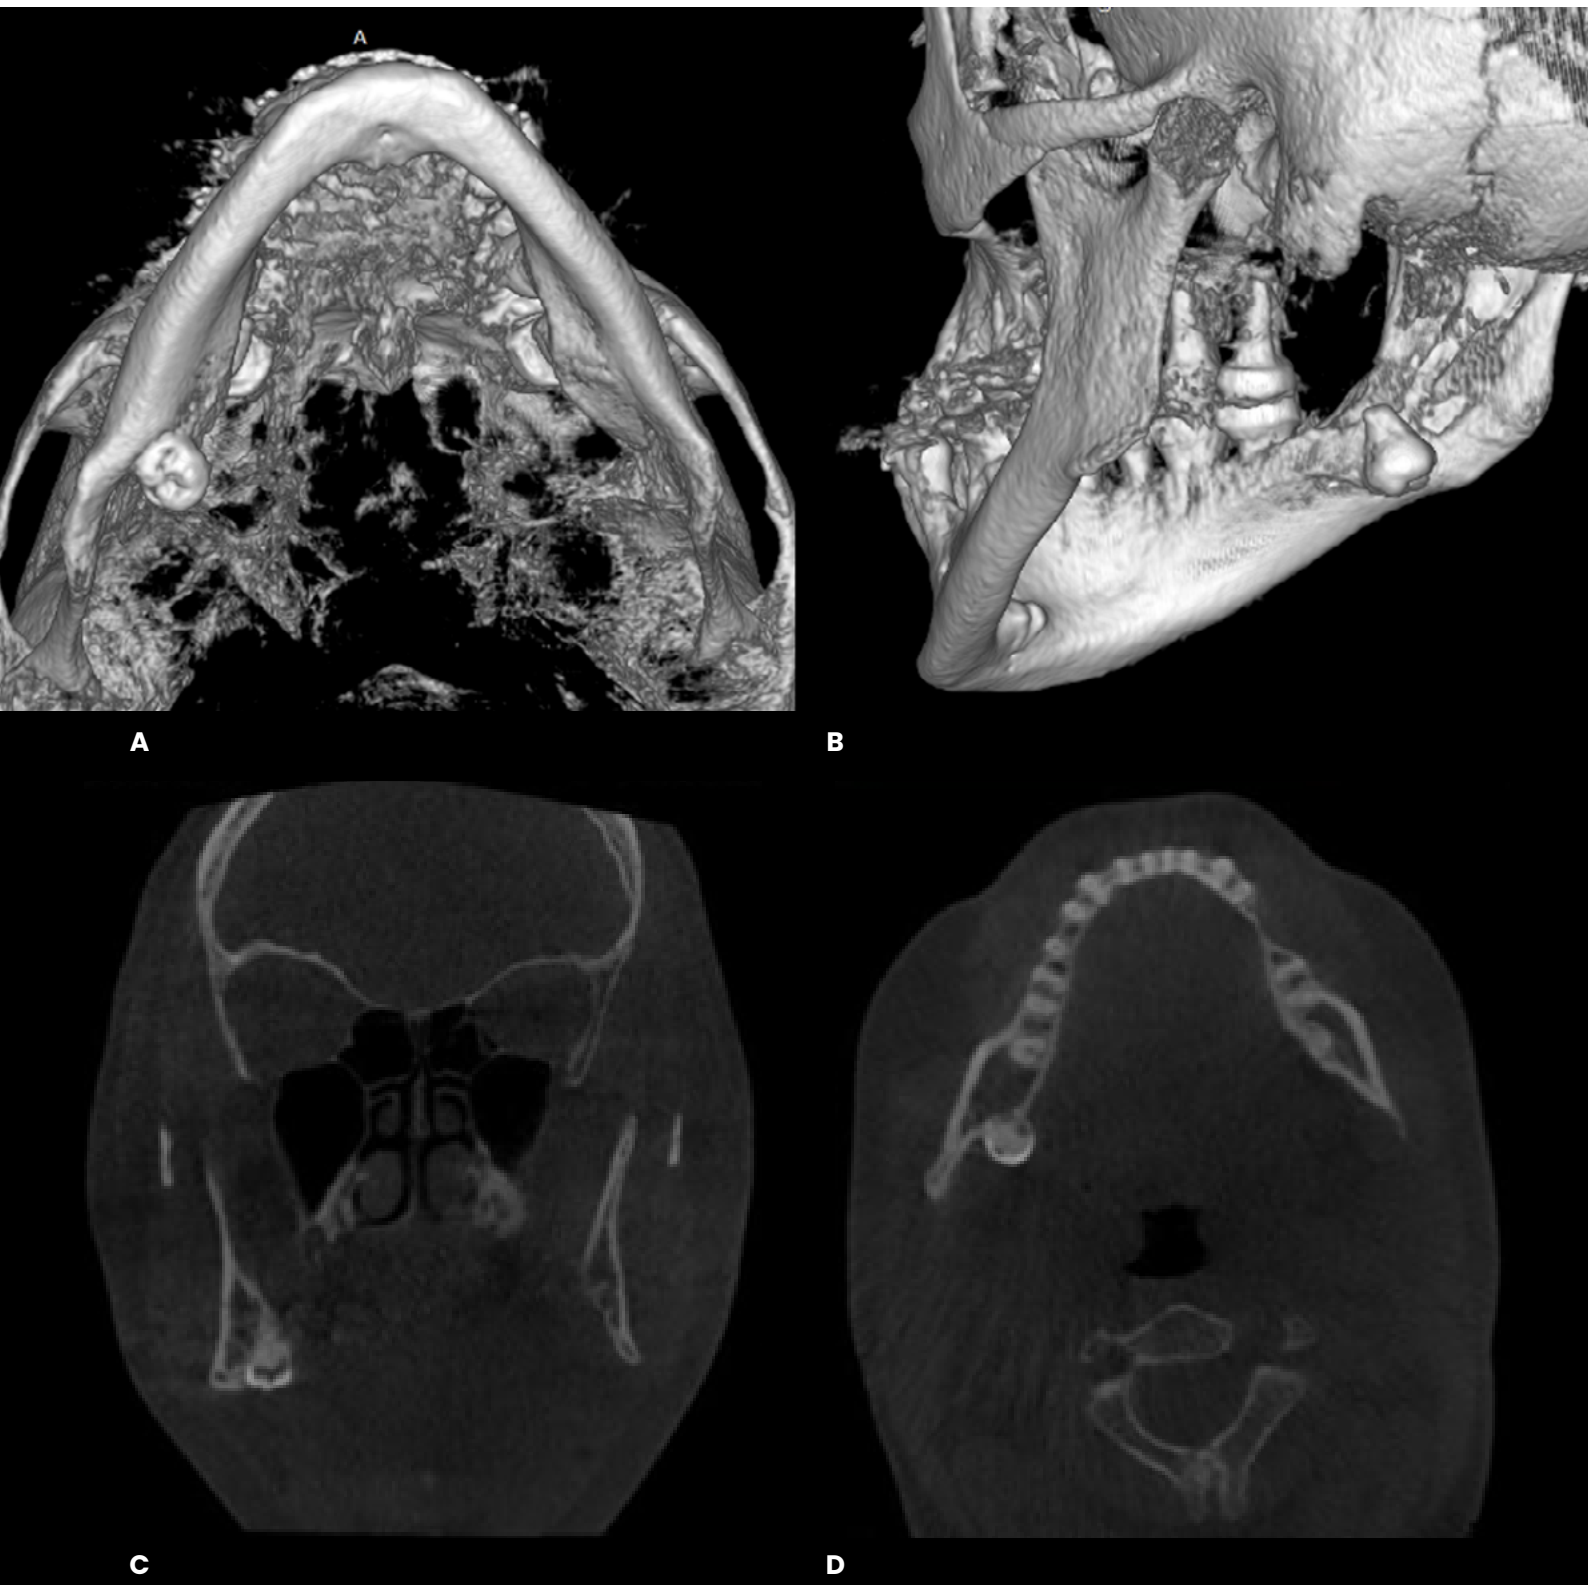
CBCT imaging study of the displaced third molar. A. Three-dimensional reconstruction, inferior view, showing the inverted position of the lower right third molar displaced toward the mandibular border. B. Oblique posteroanterior three-dimensional reconstruction, evidencing the deep location of the molar in close contact with the internal mandibular cortex. C. Coronal section showing the relationship between the molar crown and the medial cortex, with partial preservation of the periodontal space. D. Axial section showing the proximity of the root to the inferior alveolar nerve canal.
